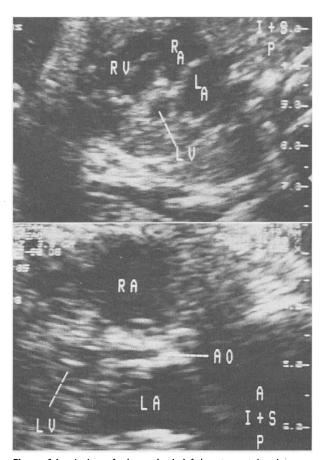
A view of a hypoplastic left heart was taken in a patient at 30 weeks' gestation and referred because the obstetrician had noted an enlarged left atrium. The top frame, taken in a 4-chamber view, shows a minute left ventricle (LV) with a thickened endocardium. The other chambers, right atrium (RA), right ventricle (RV), and left atrium (LA), can be identified. In the bottom frame, in an equivalent to a parasternal long-axis view, the minute left ventricular outflow tract and hypoplastic ventricle are identified. There appears to be no continuity between the aorta (Ao) and the left ventricle (from Schmidt and Silverman<sup>49</sup>).
